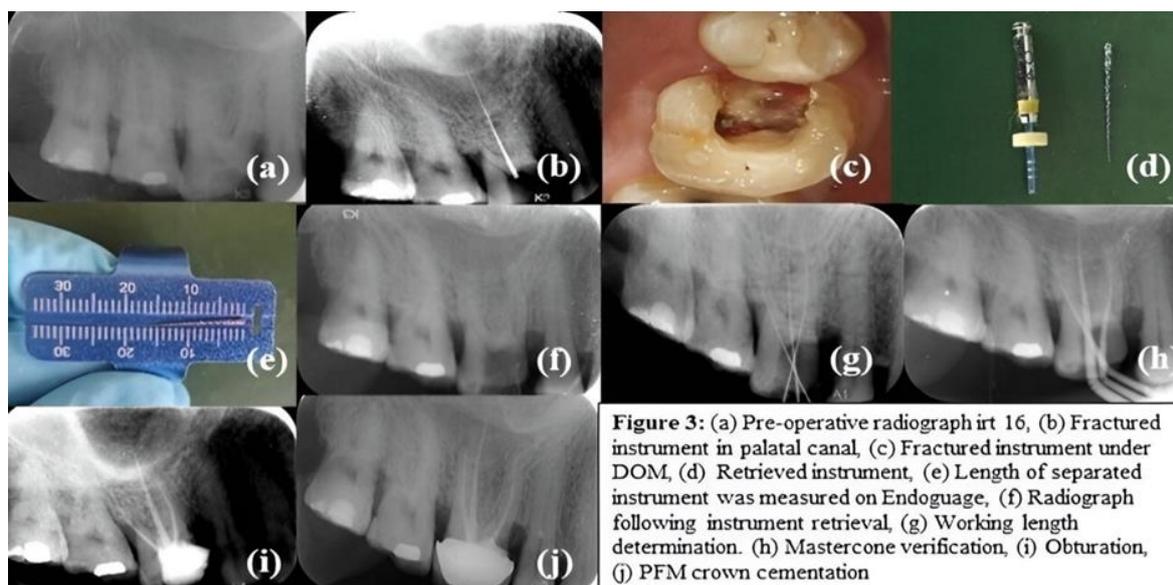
(a) Pre-operative radiograph irt 16, (b) Fractured instrument in palatal canal, (c) Fractured instrument under DOM, (d) Retrieved instrument, (e) Length of separated instrument was measured on Endogauge, (f) Radiograph following instrument retrieval, (g) Working length determination. (h) Mastercone verification, (i) Obturation, (j) PFM crown cementation
